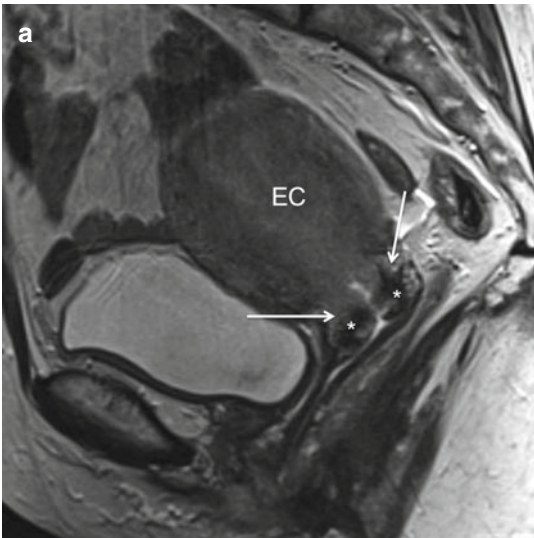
(a, b) Cervical stromal infiltration (stage II). Sagittal TSE T2-weighted image (TR/TE 2,400/76 ms) (a) shows a large endometrial carcinoma (EC), infiltrating more than 50 % of myometrial thickness, which reaches the cervical structures (arrows) and interrupts the physiological hypointensity of cervical stroma
